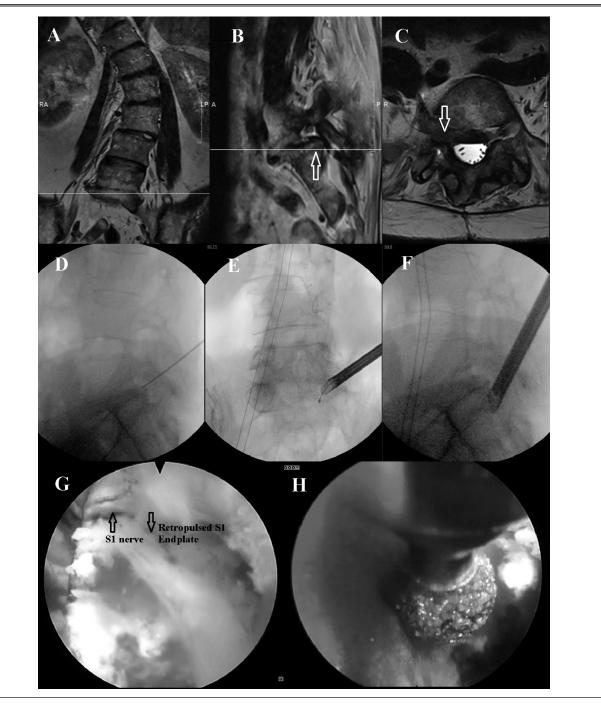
L5-S1 spondylolisthesis in a patient after 12 surgeries for scoliosis. (A) Sagittal T2-weighted coronal magnetic resonance imaging (MRI) demonstrating severity of coronal scoliosis despite 12 previous surgeries. (B) Sagittal T2-weighted MRI demonstrates the severity of the right S1 nerve compression form the retropulsed posterior superior corner of the S1 vertebral body endplate (arrow). (C) Axial T2-weighted MRI shows the obliteration of the right L5-S1 foramen (arrow). (D) Lateral fluoroscopic image shows needle targeting at the posterior superior corner of the S1 vertebral body endplate. (E) AP fluoroscopic image shows the beveled tubular retractor in the right L5-S1 foramen. (F) Lateral fluoroscopic image shows the beveled tubular retractor placed directly on the S1 vertebral body (under the S1 nerve). (G) Endoscopic camera view from Fig. 3F of the bone compressing the S1 nerve. (H) Endoscopic camera view of the Shrill drill used to reduce the bone endplate of S1 and decompress the S1 nerve.
